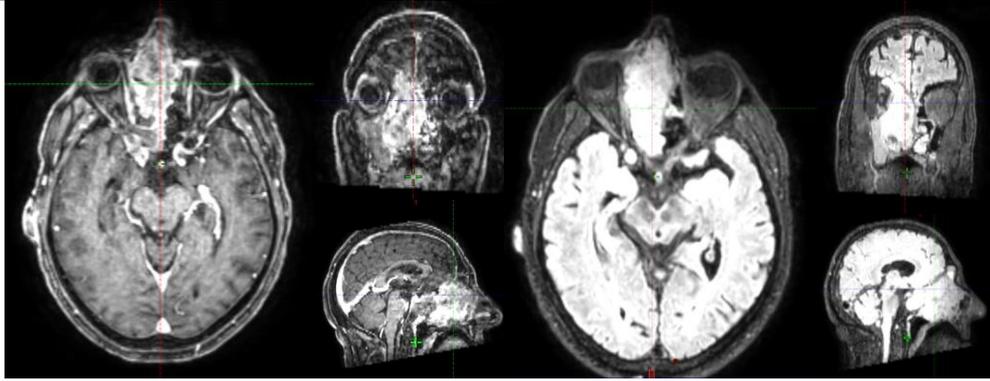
Cervicofacial MRI in T1 injected and T2 sequences indicating a 30% reduction in tumor size after neoadjuvant chemotherapy
